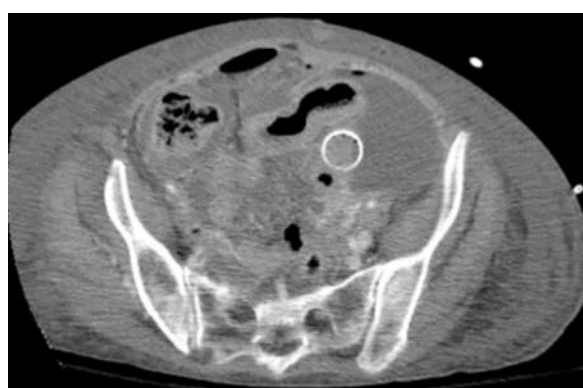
Computed tomography scan reveals a stent in the small bowel protruding intra-peritoneally with pneumoperitoneum.
